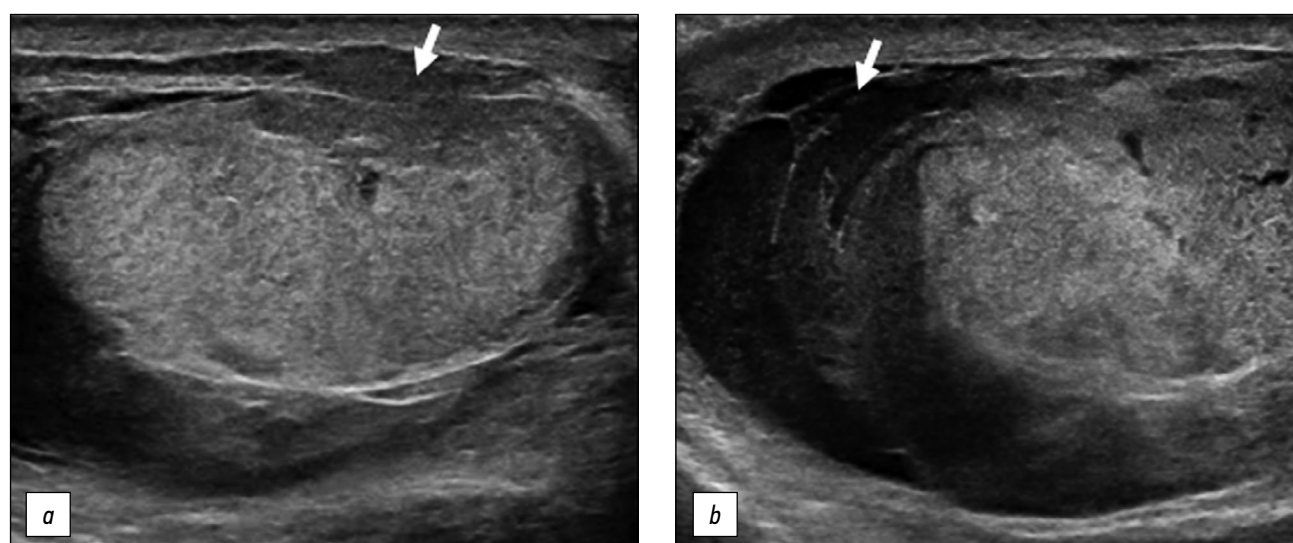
B-mode ultrasonography images. (a) Interruption of the tunica albuginea with the protrusion of echogenic material (arrow) that represents an index of breaking. (b) Hematocele of moderate size (arrow) and a heterogeneous appearance of testicular parenchyma, attributable to an intratesticular contusion.
